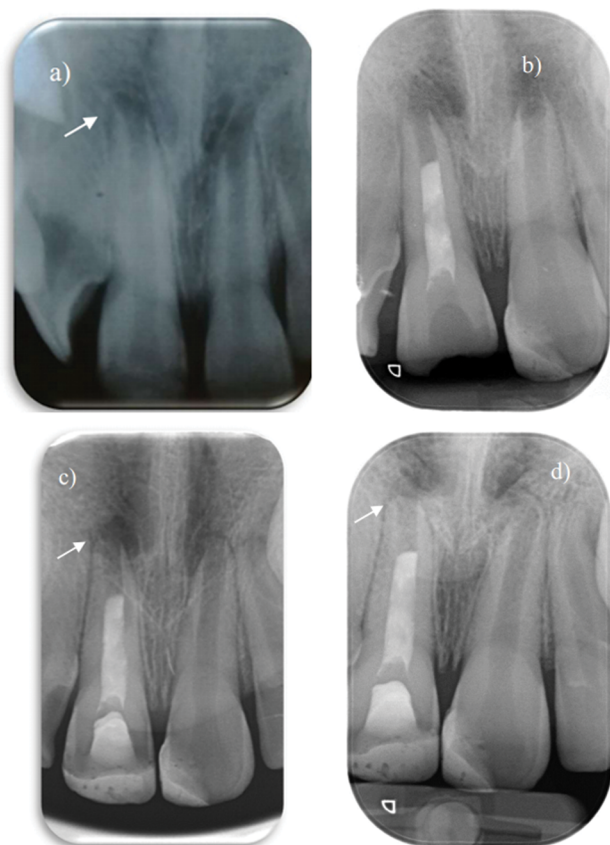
Lack of radiographic signs of healing process. a) Initial X-ray; b) Follow-up after revascularization; c) Follow-up after 6 months; d) Follow-up after 18 months.
